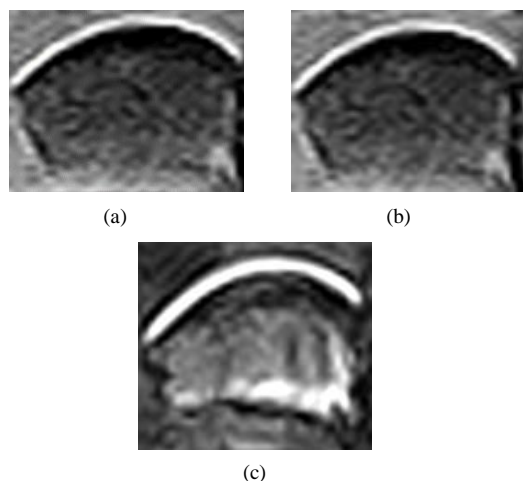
MRI images from different imaging sequences: (a) Gradient Echo; (b) Spin Echo; (c) Turbo 3D.
